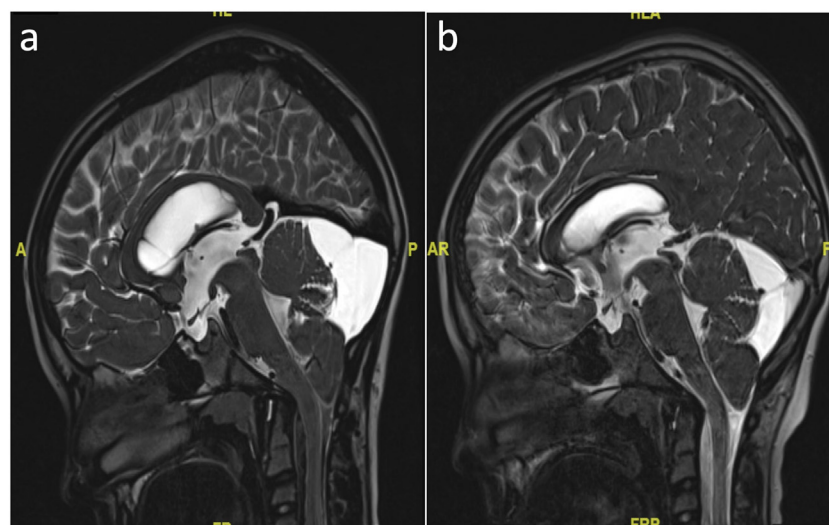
Magnetic Resonance Image (MRI) showing the third ventricle stoma and posterior fossa anatomy after surgery. a) Preoperative sagittal T2 sequence MRI showing a crowded posterior fossa and distended III ventricle. b) Postoperative sagittal T2 sequence MRI showing a patent stoma and flow in the floor of the III ventricle after endoscopic third ventriculostomy and relaxed posterior fossa. However, the herniation of the tonsils did not change significantly.
